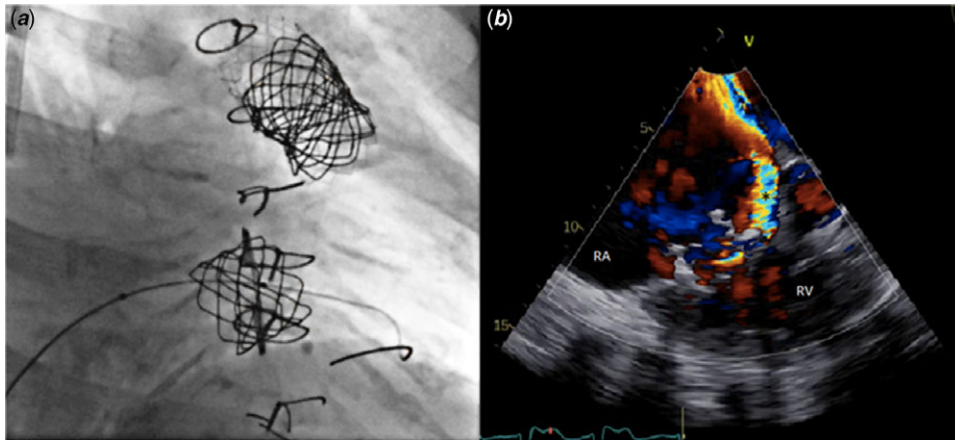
(a) Catheterisation fluoroscopy, anteroposterior view. Two 22 mm Melody® valves implanted in the pulmonary position (valve-in-valve, upper valve) and in tricuspid position (valve-in-ring, lower valve). (b) 2D transesophageal echocardiography colour doppler mode, four chambers view. Melody® valve implanted successfully inside Carpentier ring with moderate paravalvular leakage. Legend: * - paravalvular leakage; RA - right atrium; RV - right ventricle.
